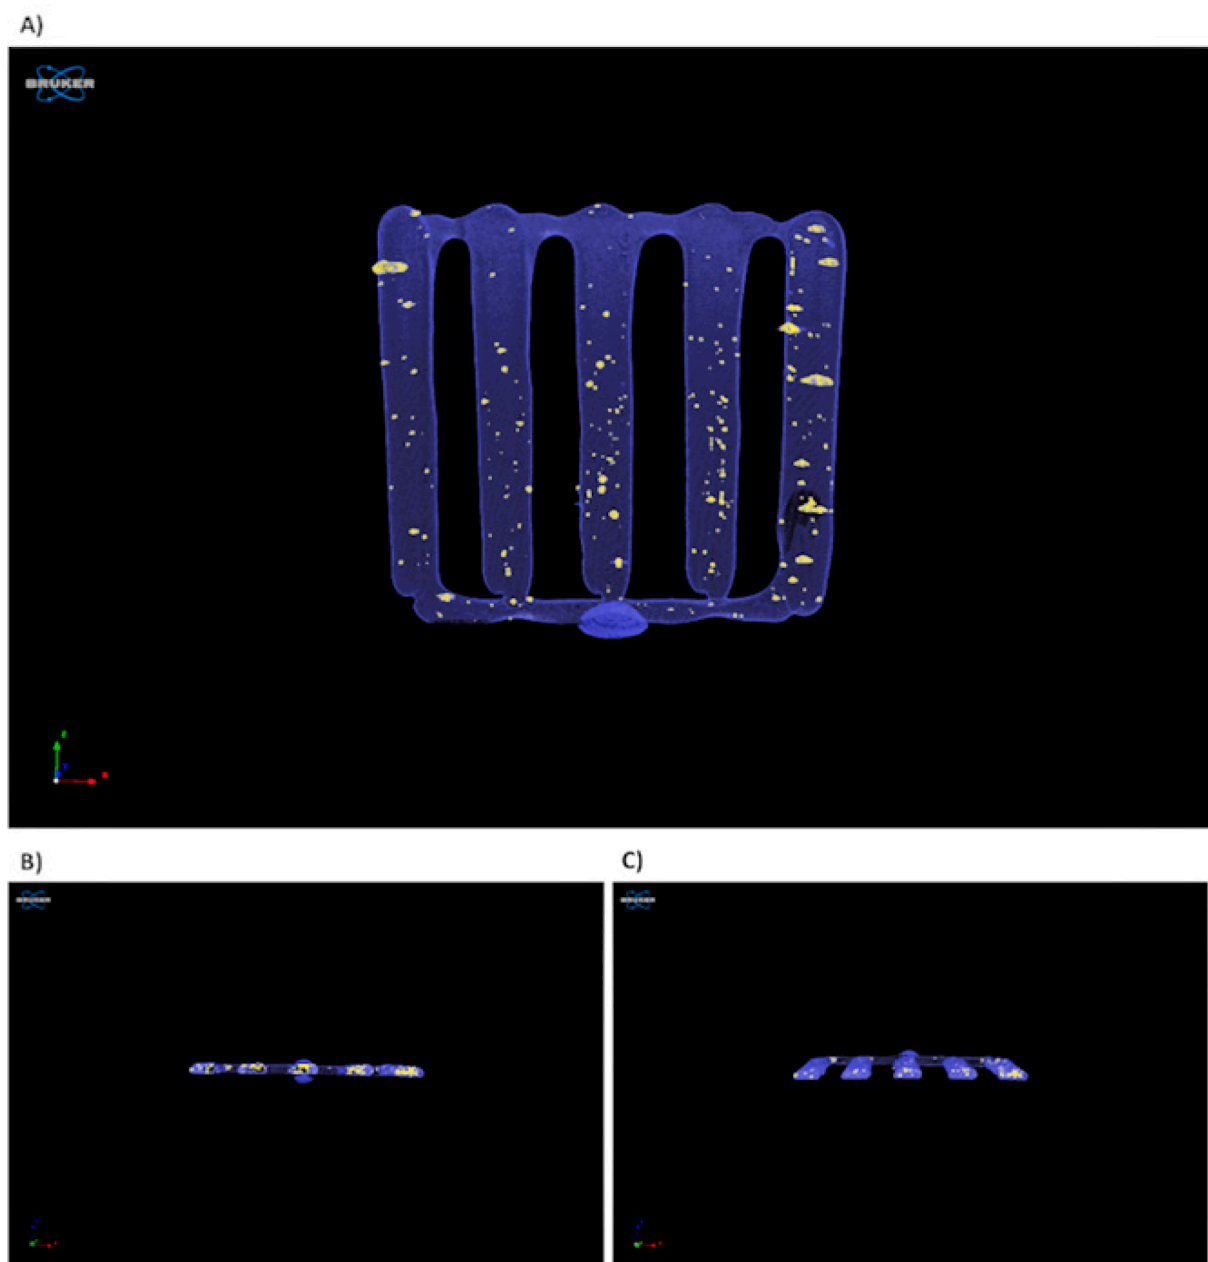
X-ray microcomputed tomography reconstruction (3D slices) of the printed implant. A) Front view; B) Inferior view; C) Superior view.
